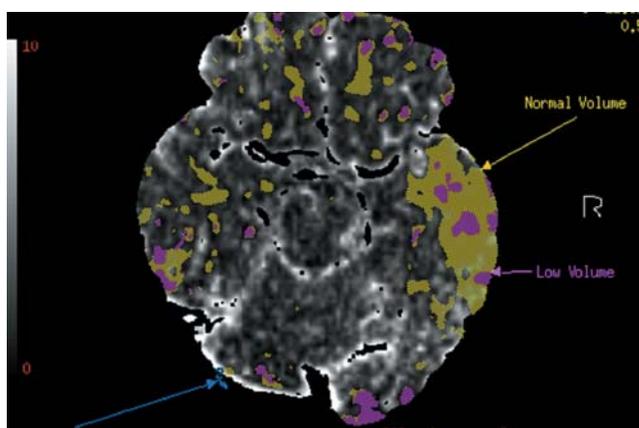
Perfusion CT data demonstrate small dead brain tissue foci (purple) and the large area of viable penumbra (orange).
